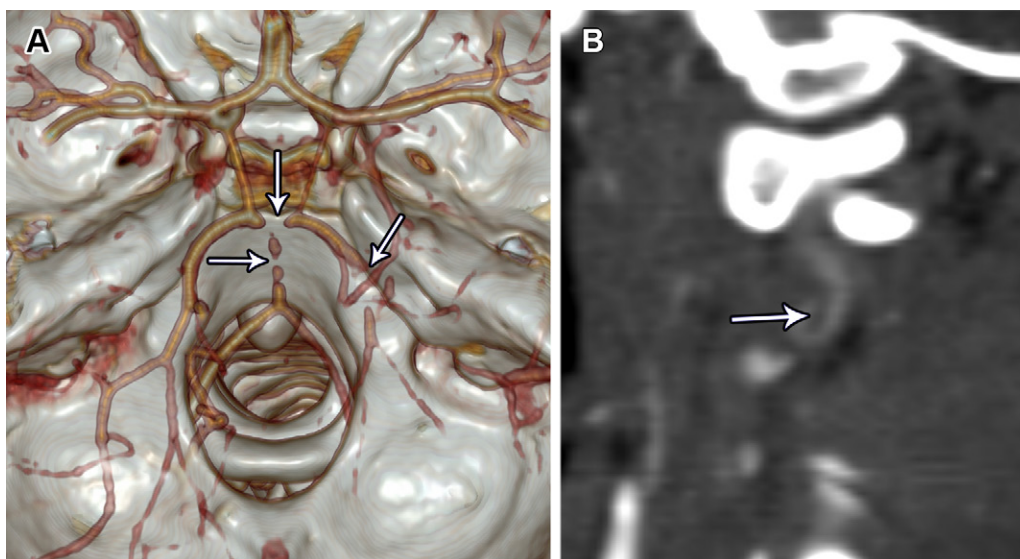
Posterior circulation arterial occlusions and VAD in a 6-year-old girl with left-sided weakness and facial sensory changes. (A) Superior volume-rendered CT angiogram shows abrupt and multifocal occlusions (arrows) of the basilar and right posterior cerebral arteries. (B) Sagittal multiplanar reformation CT angiogram shows segmental stenosis of the right vertebral artery at the proximal V3 level, with a possible intimal flap (arrow). Abrupt posterior circulation arterial occlusions suggest thromboembolism (usually vessel-to-vessel) and should prompt a search for VAD at cervical vascular imaging.
